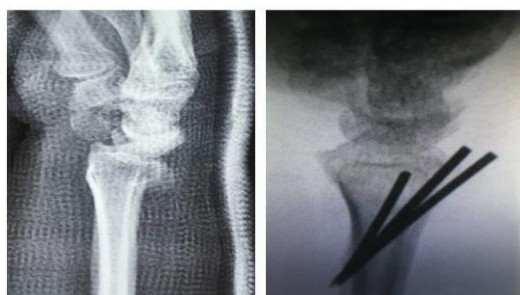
Preop & Postop X-ray Lateral View
